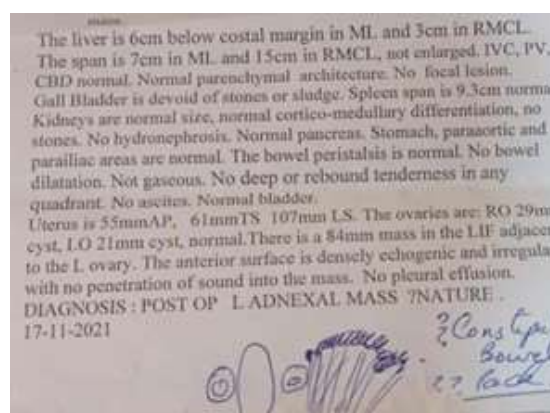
Ultrasound scan showing an adnexal mass
